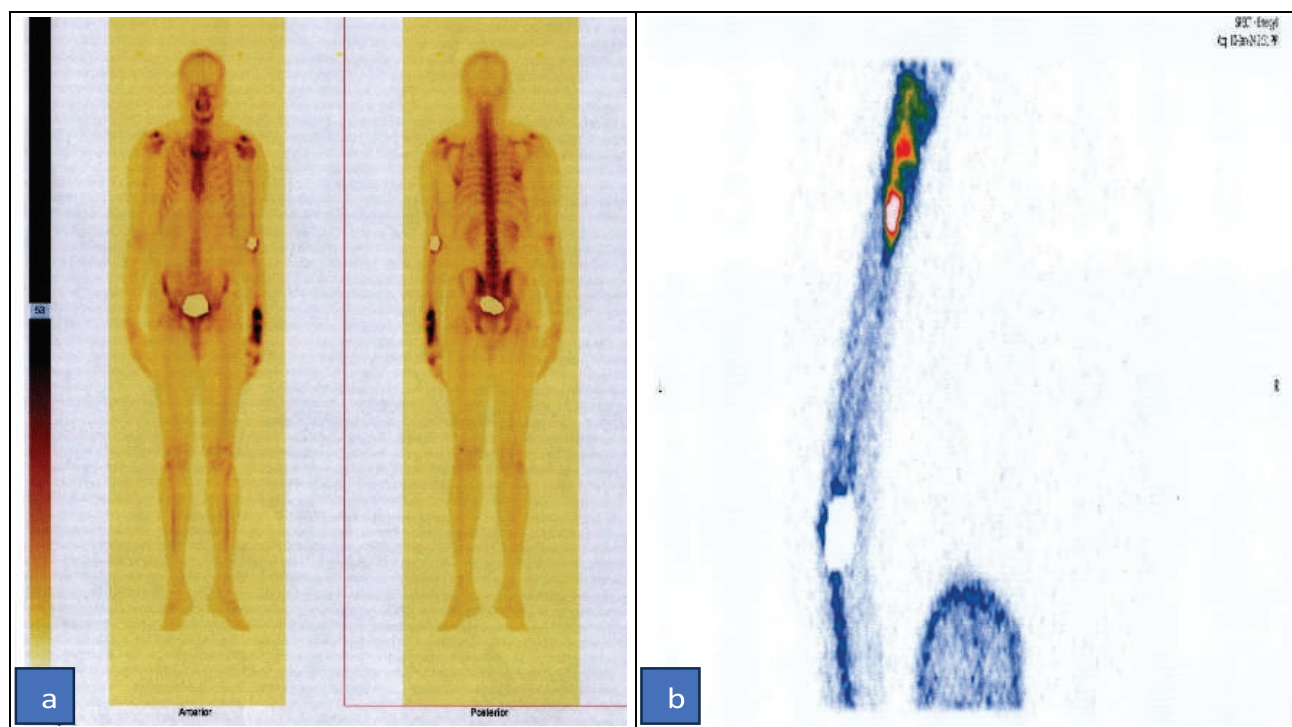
Images showing focal increased radiotracer uptake in distal end of radius at ^{99m}Tc -MDP bone scintigraphy Planar image-(a) and SPECT image-4(b).
